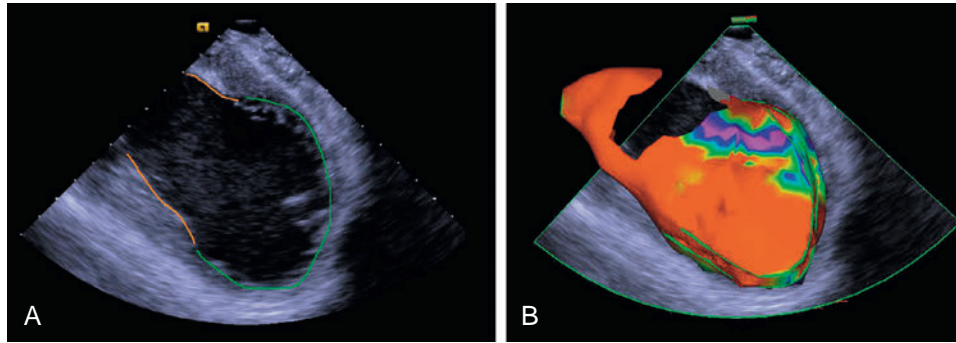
The CARTO-Sound Image Integration Module to Guide Scar-Related Ventricular Tachycardia Ablation. (A) Intracardiac echocardiographic (ICE) image showing a long-axis view of the left ventricle (LV) using a 10 Fr phased-array transducer catheter. The endocardial surface of the LV is traced. Note aneurysmal wall thinning of the anteroapical of the LV (traced in green) as compared with normal wall thickness in the LV base (traced in red). (B) Integration of the CARTO-Sound volume and the electroanatomic voltage map of the LV (modified anterior view).
